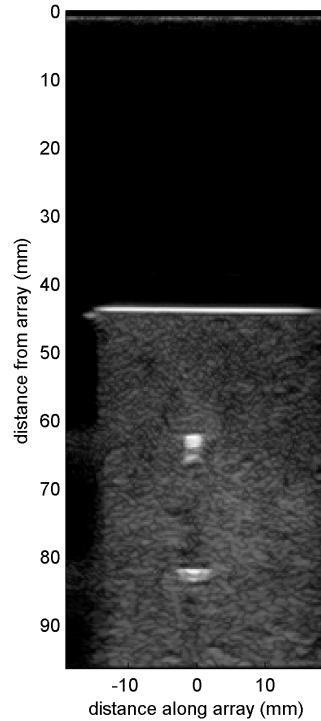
B-mode ultrasound image of flow channels in agar gel. The two channels are located 63 mm and 83 mm from the array, and the HIFU focus is positioned exactly half-way between them at 73 mm from the array. A highly hydrophobic talc suspension is flowing through both channels, hence their brightness. Since talc suspension has a much lower cavitation threshold, judicious choice of the HIFU intensity can cause cavitation in both channels without causing cavitation in the surrounding agar gel. The apparent difference in channel widths is due to the depth-dependent lateral resolution of the image.
